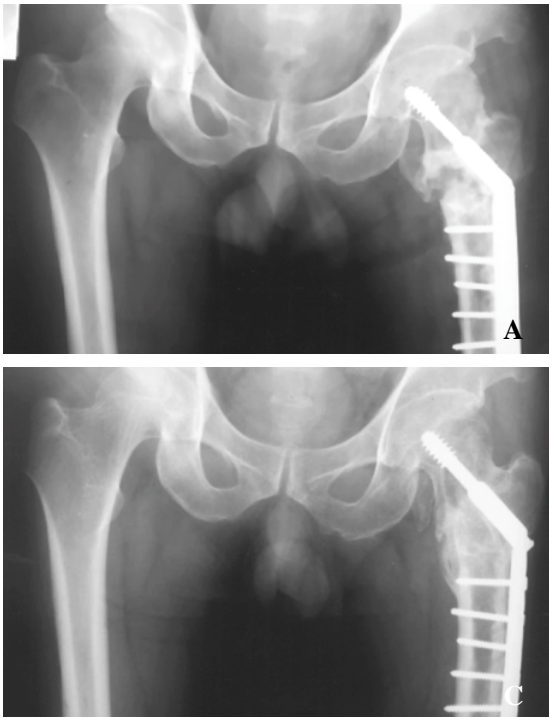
A. Anteroposterior radiograph of the both hip. At the time of reoperation, impacted cancellous allograft, valgus fixation and autograft are done.
